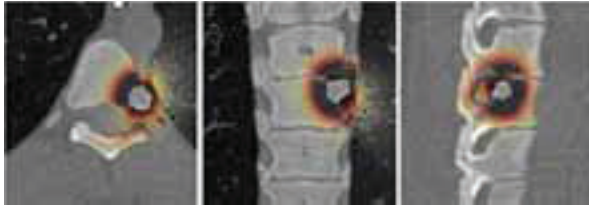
Dose distribution delivered by the needle, computed by the hybrid Monte Carlo algorithm in the transverse, coronal and sagittal plans of a patient spinal CT scan. Dose leaking can be appreciated into the lung area.
